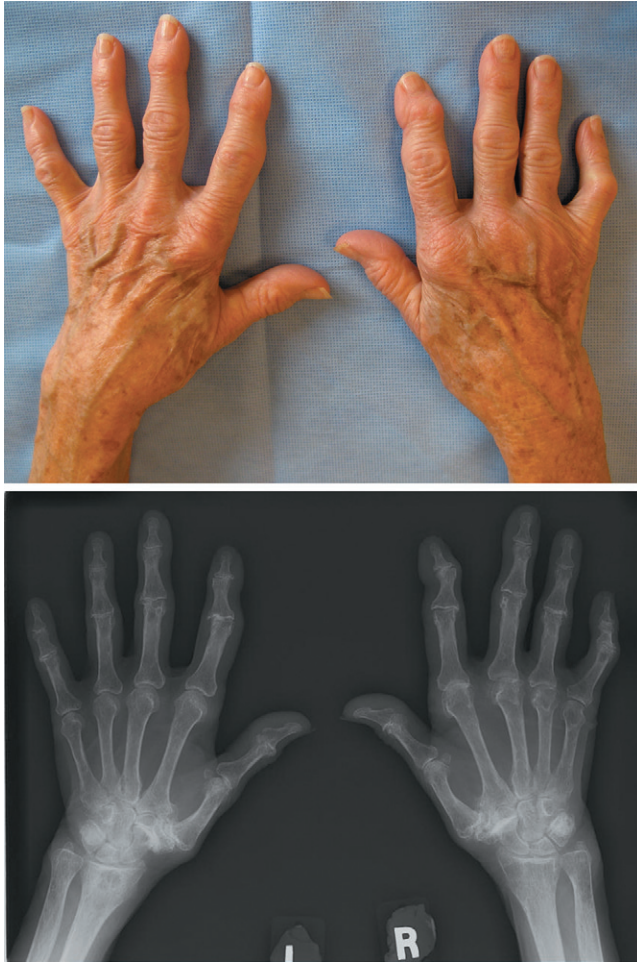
Hands of a 79-year-old woman showing clinical (*top*) and radiographic (*bottom*) features of osteoarthritis (OA). This patient has Heberden's and Bouchard's nodes of multiple digits; radiographs show osteophytes, joint space narrowing, and cysts typical of OA, as well as "gull-wing" deformities at the third proximal interphalangeal joints suggestive of erosive OA.
